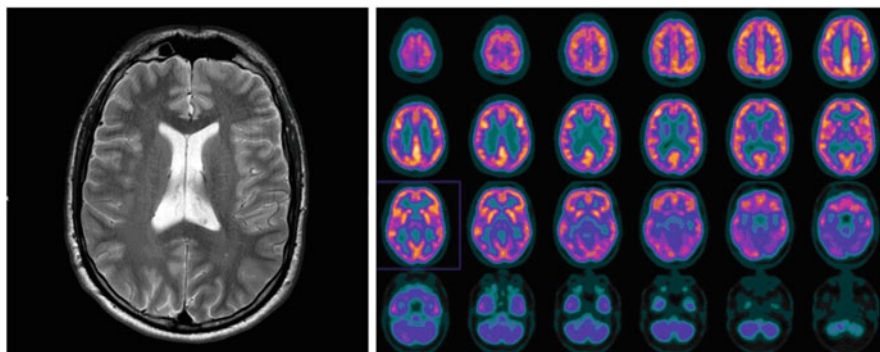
MRI (left) and FDG-PET (right) images
